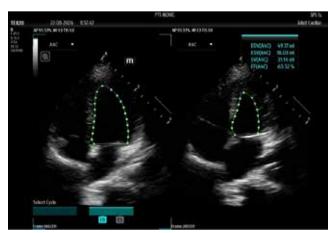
Ultrasound image of AI tool used for automated Ejection Fraction.
